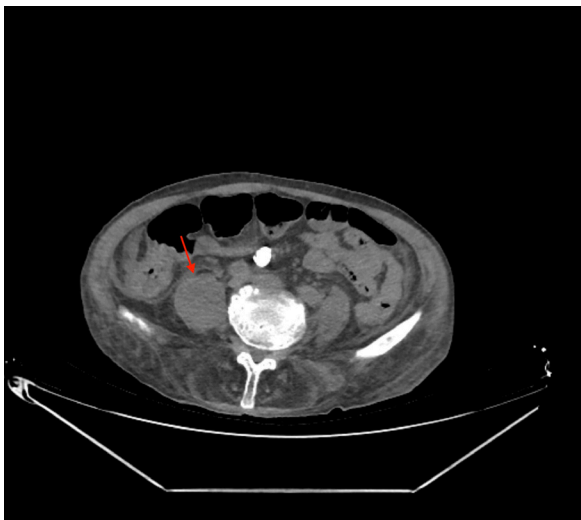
Abdominal CT showing a 43-mm fluid collection with gas formation in the right psoas muscle
